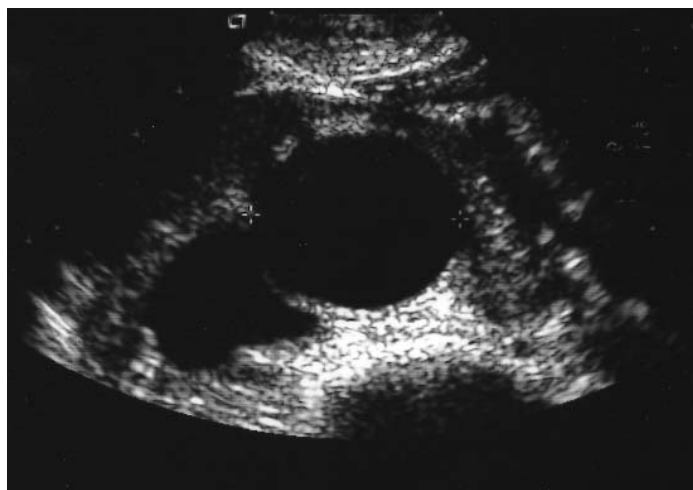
Duplex ultrasonography may be used as a screening test and to determine the actual size of the aneurysm.
